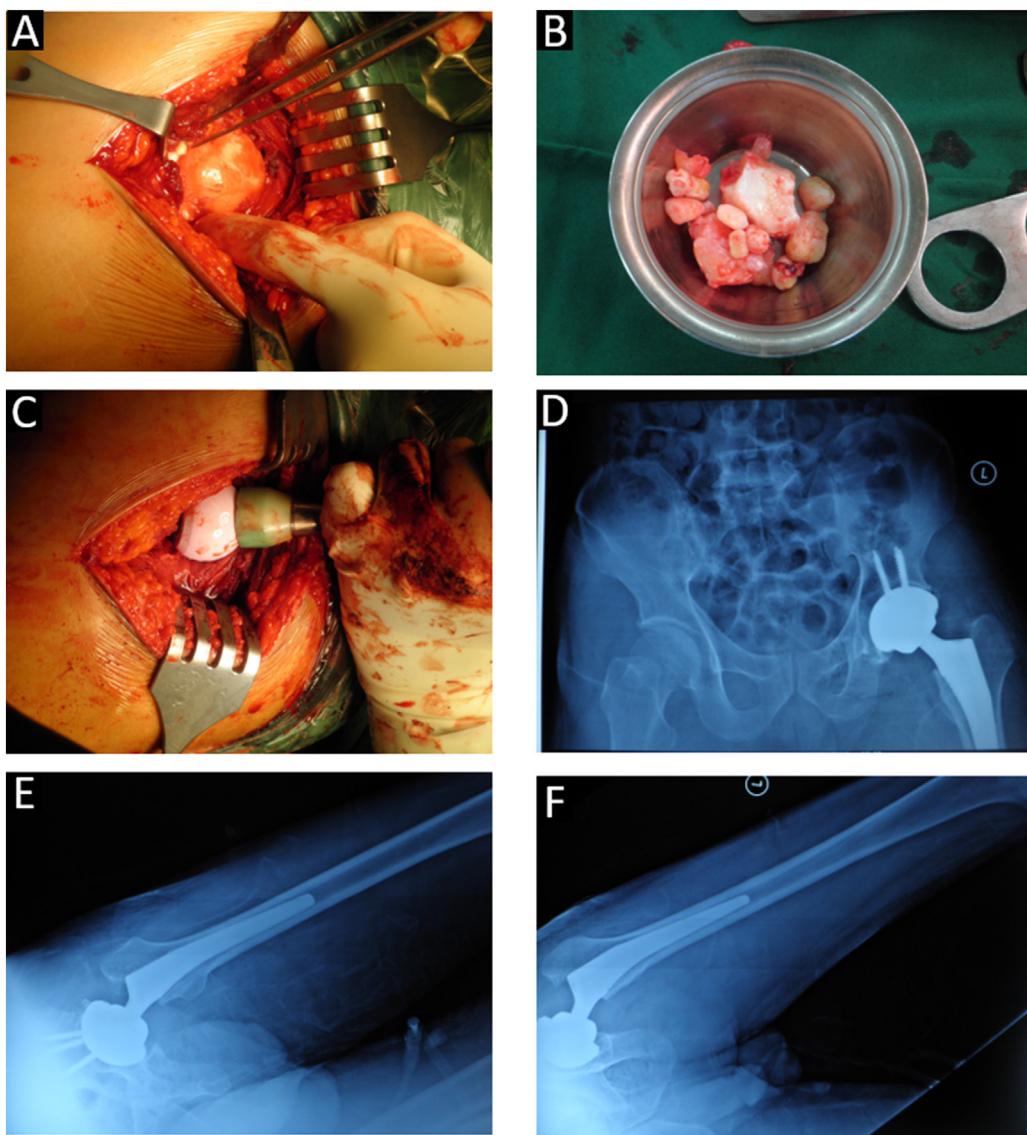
(A) Femoral head after hip dislocation, osteoarthritis of the joint was observed with pale surface, and osteophyte formation, intra- and extracapsular loose bodies were observed; (B) Evacuation of 15 loose bodies was performed; (C) Installation of ceramic-on-ceramic prosthesis was performed; (D–F) Postoperative x-ray.
